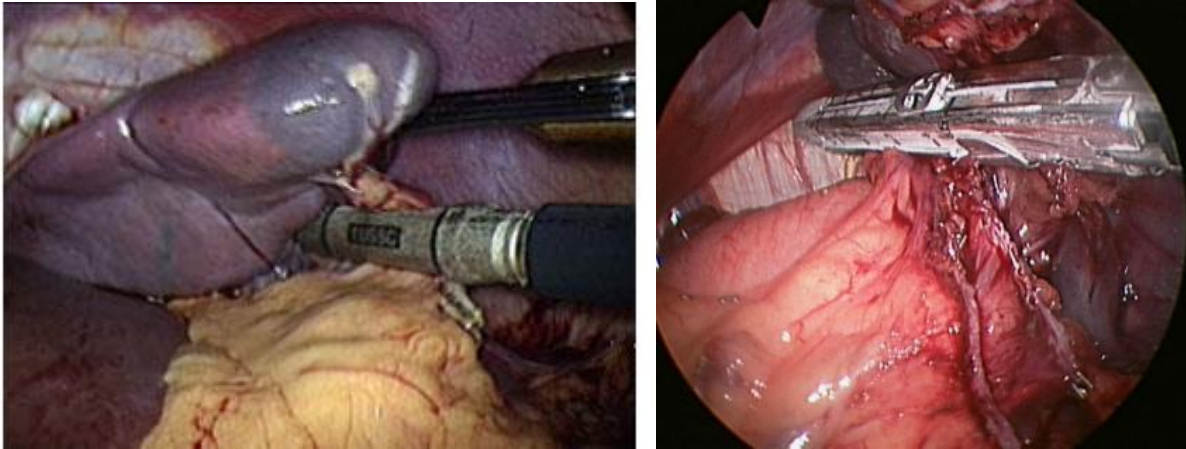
Surgical stapling devices and ultrasonic shears for vascular control
